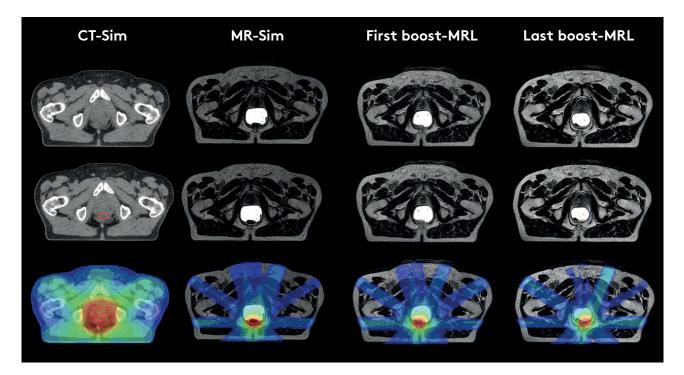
Example of CT-Sim, MR-Sim and Elekta Unity images for treating a rectum patient with an adaptive boost to the target. While on CT imaging no boost volume can be defined, this is clearly visible on MR images. Moreover, the different location of the target between the first and last boost shows the importance of adapting the boost volume.
